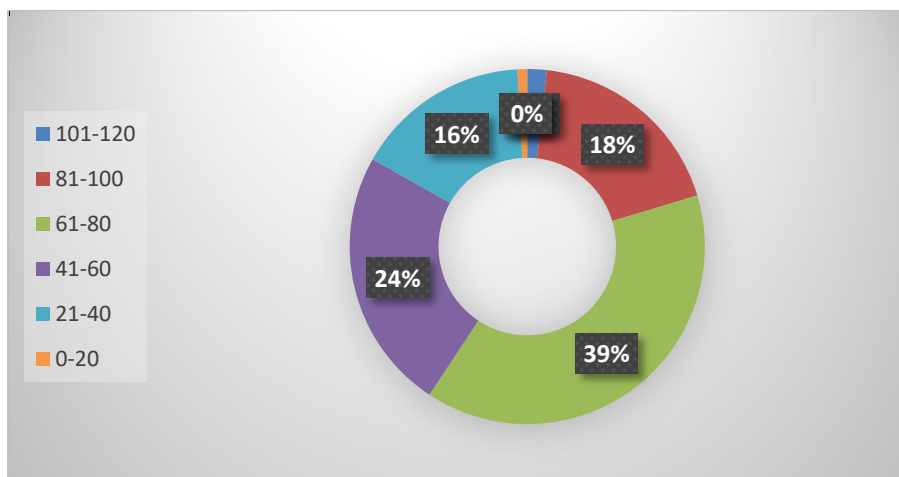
shows number of cases that detected by CTA, for different age range
